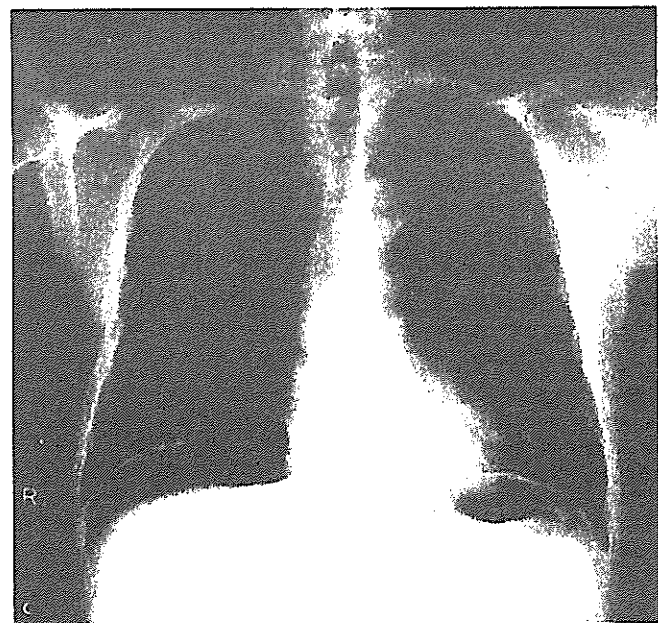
Endoscopic view of the transverse colon, showing a perforation (arrow) that occurred during sub-mucosal dissection (a), and the view after closure of the perforation using endoclips (b). The chest radiograph showed pneumoperitoneum (c).
